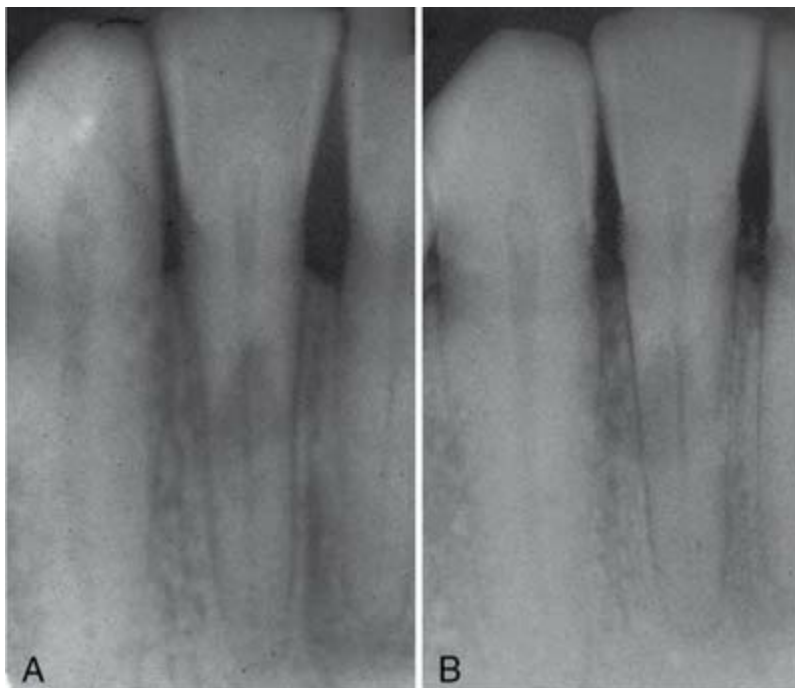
External root resorption. Radiographs from two different horizontal projections depict movement of the lesion to outside the confines of the root canal.
